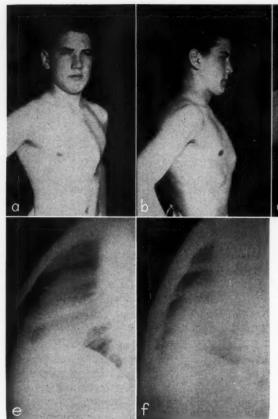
Patient J. Z., aged sixteen, Pectus Carinatum. (a and b) Before operation. (c and d) After operation. (e) Lateral chest x-ray before operation. (f) Lateral chest x-ray after operation.
